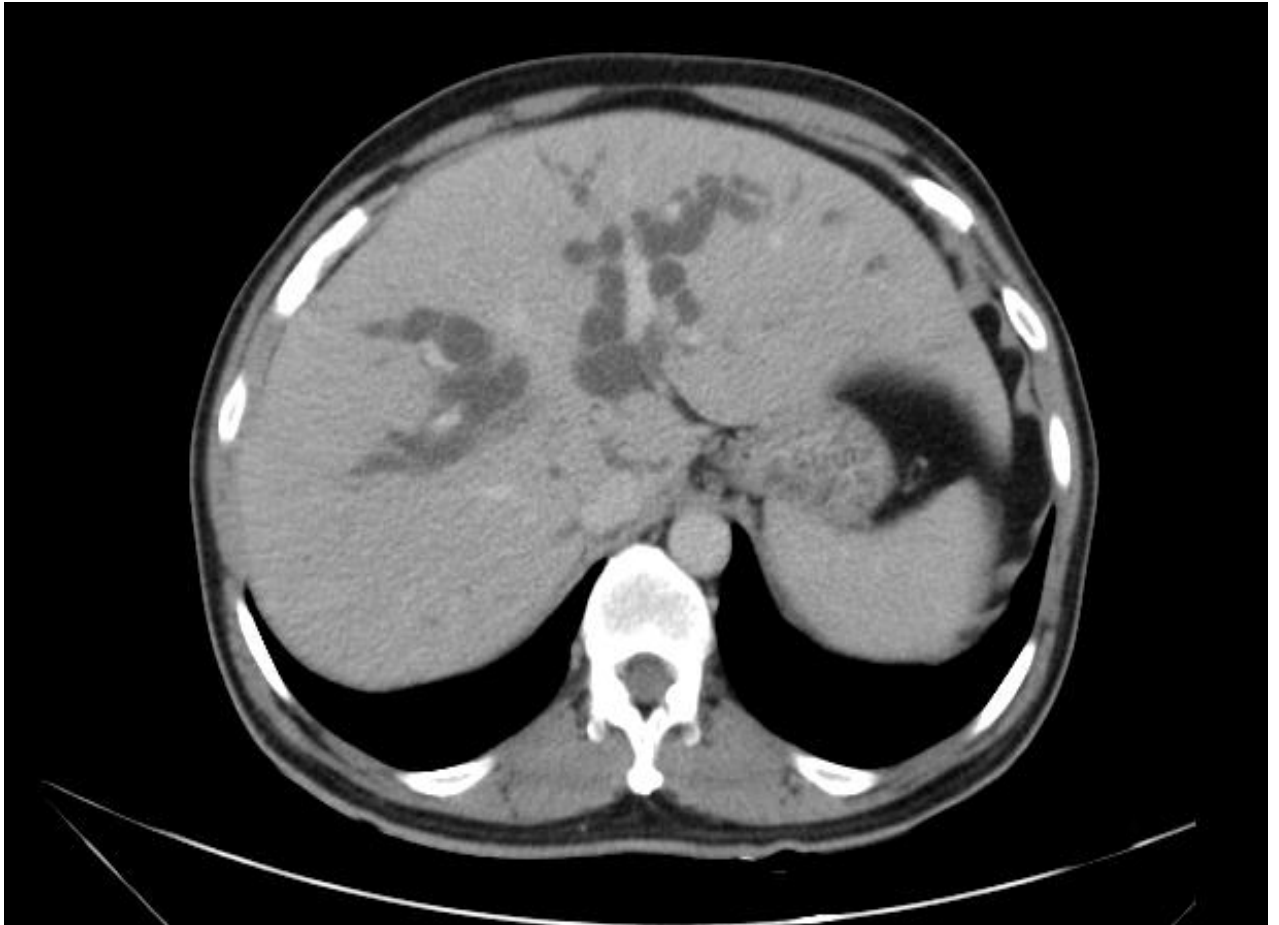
Contrast enhanced CT scan of the abdomen showing intrahepatic biliary radicle dilatation in a patient with periampullary carcinoma
